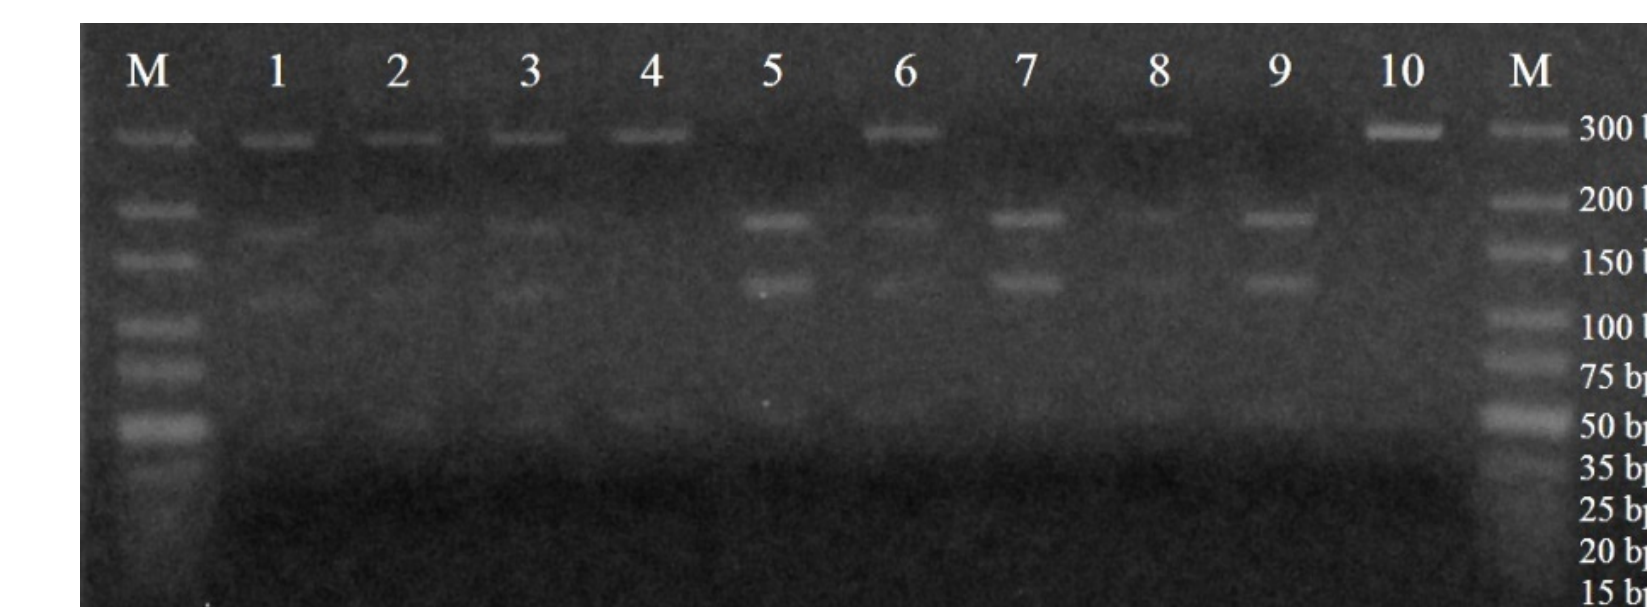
Agarose gel electrophoresis of RFLP products for MMP8 -799C>T (rs11225395) polymorphism analysis. Lane M - DNA molecular marker GeneRuler Ultra Low Range DNA Ladder (Thermo Fisher Scientific Baltics, Lithuania); Lanes 1-3, 6 and 8: CT genotype; Lanes 5, 7 and 9: CC genotype; Lanes 4 and 10: TT genotype.
